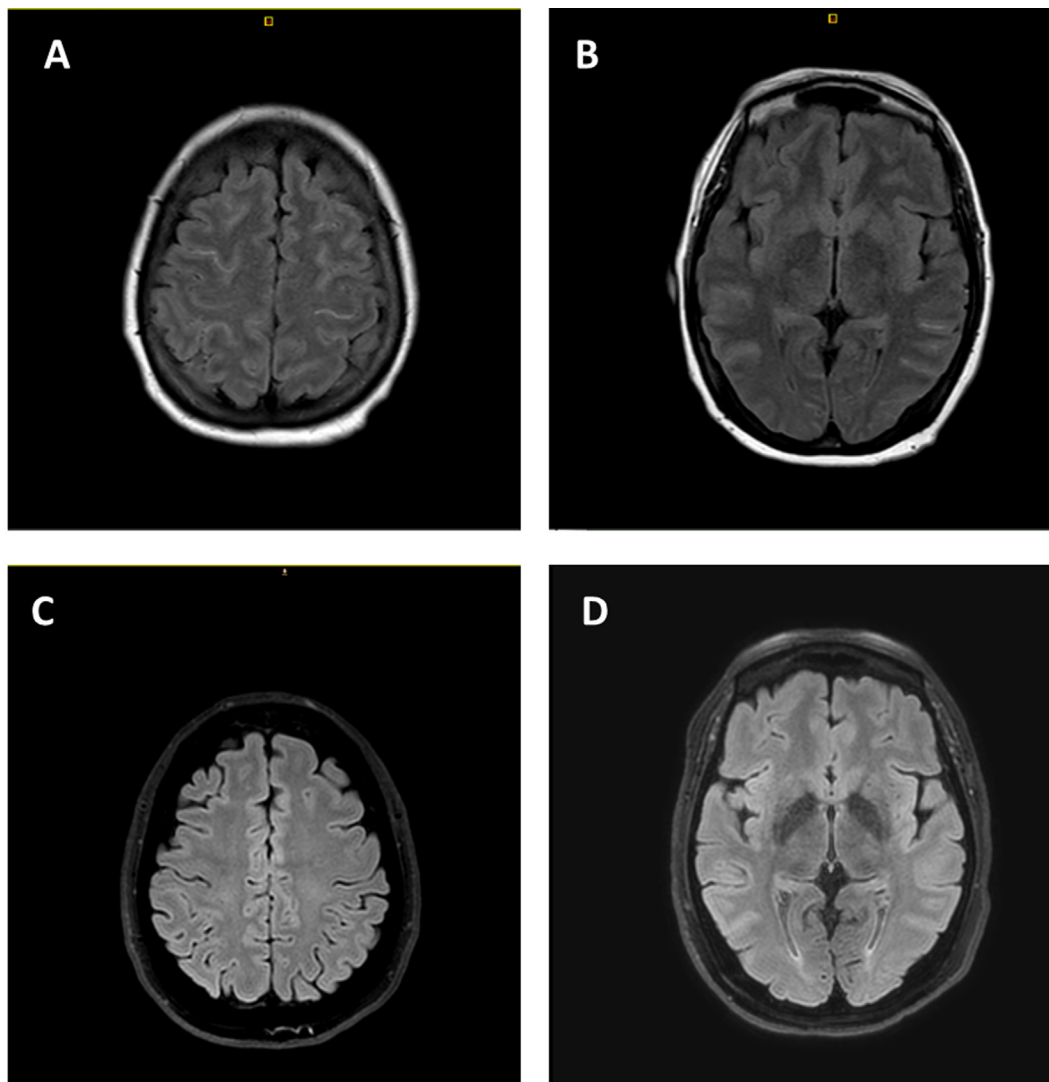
A-B. MRI during the acute phase of the intoxication, showing non-specific meningeal FLAIR hyperintensity. C-D. Normal control MRI one year later.
